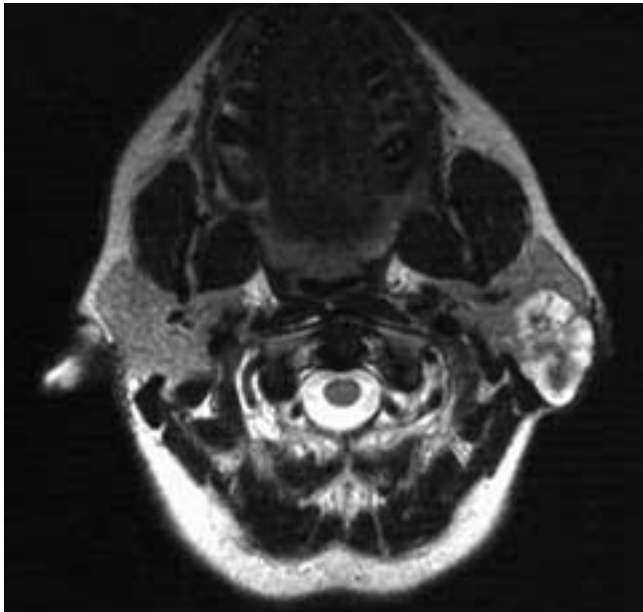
Axial T2-weighted MR image shows a nonhomogeneous but primarily high signal intensity, well-delineated mass in the left parotid gland. Although this is a nonspecific appearance, it is suggestive of a pleomorphic adenoma. The patient had a pleomorphic adenoma.
